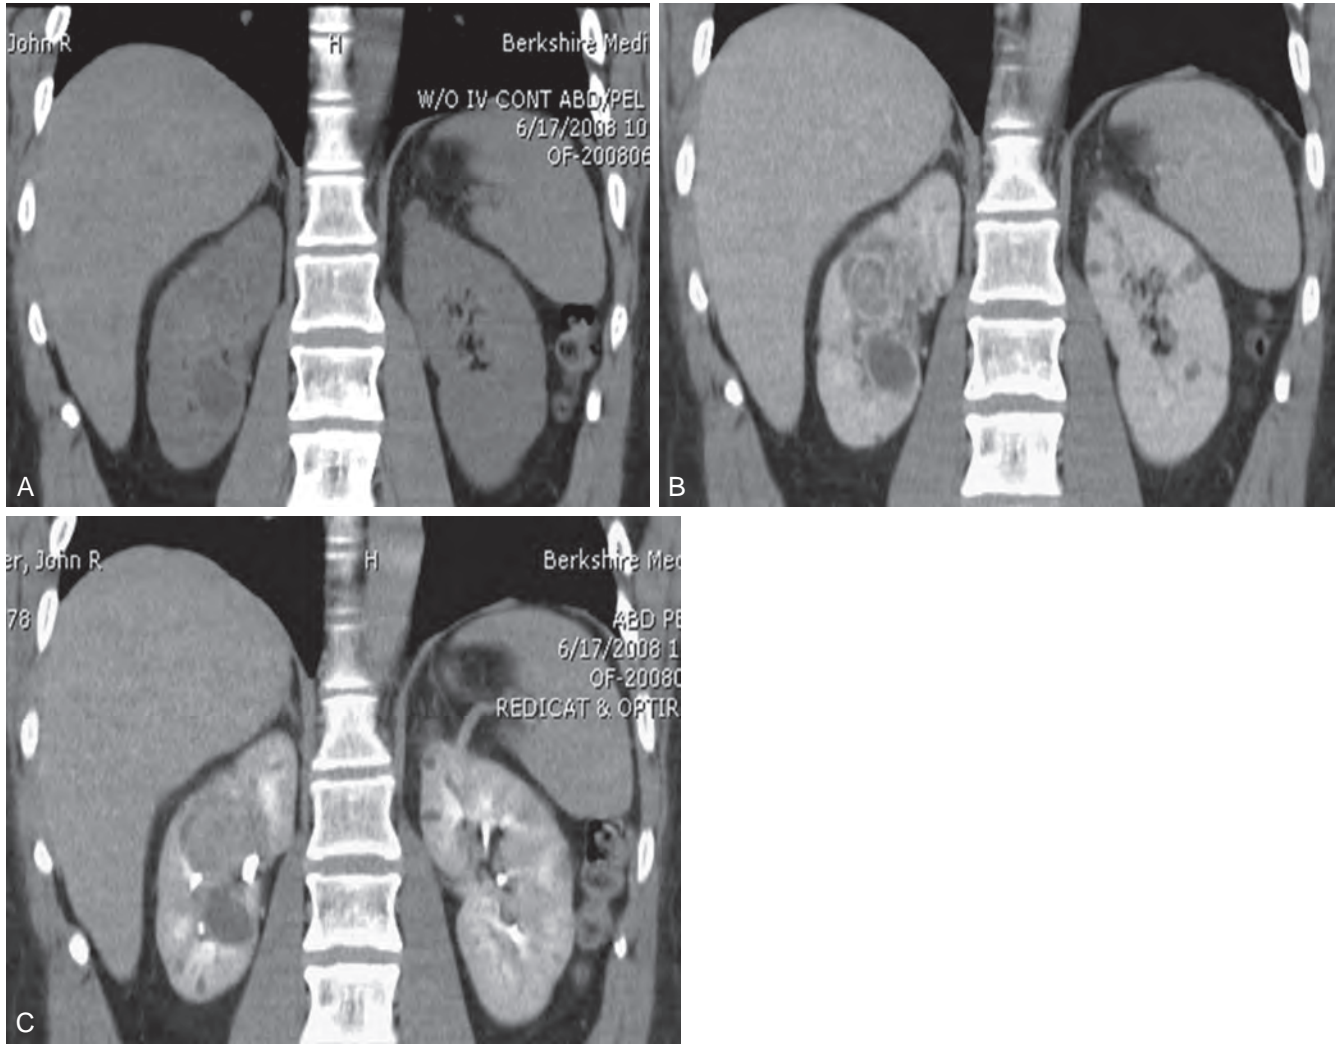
A, Preoperative computed tomography imaging demonstrates a large (4-cm) hilar lesion during a noncontrast film in a patient with a history of von Hippel-Lindau disease. B, Contrast administration demonstrates enhancement of a large intrarenal mass and nearby simple cyst. C, Delayed images depict close proximity to collecting system.
